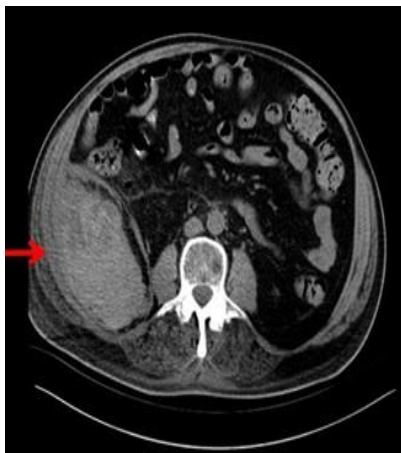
Computed tomography scan revealed a mass in the posterior abdominal wall.
